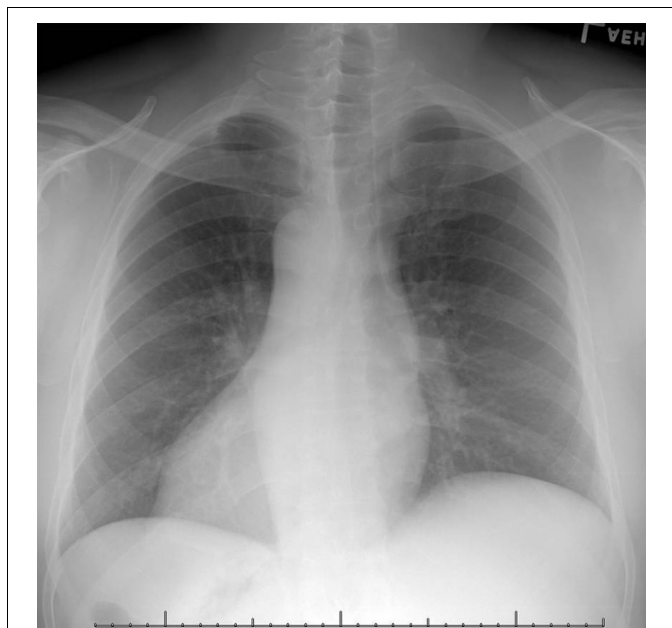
Chest X-ray with situs inversus dextrocardia showing part of the stomach air on the right side.
